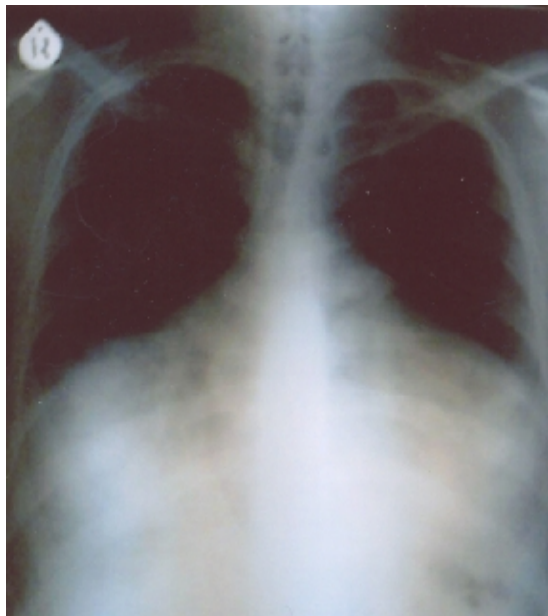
Chest x-ray in favor of cardiomegaly
